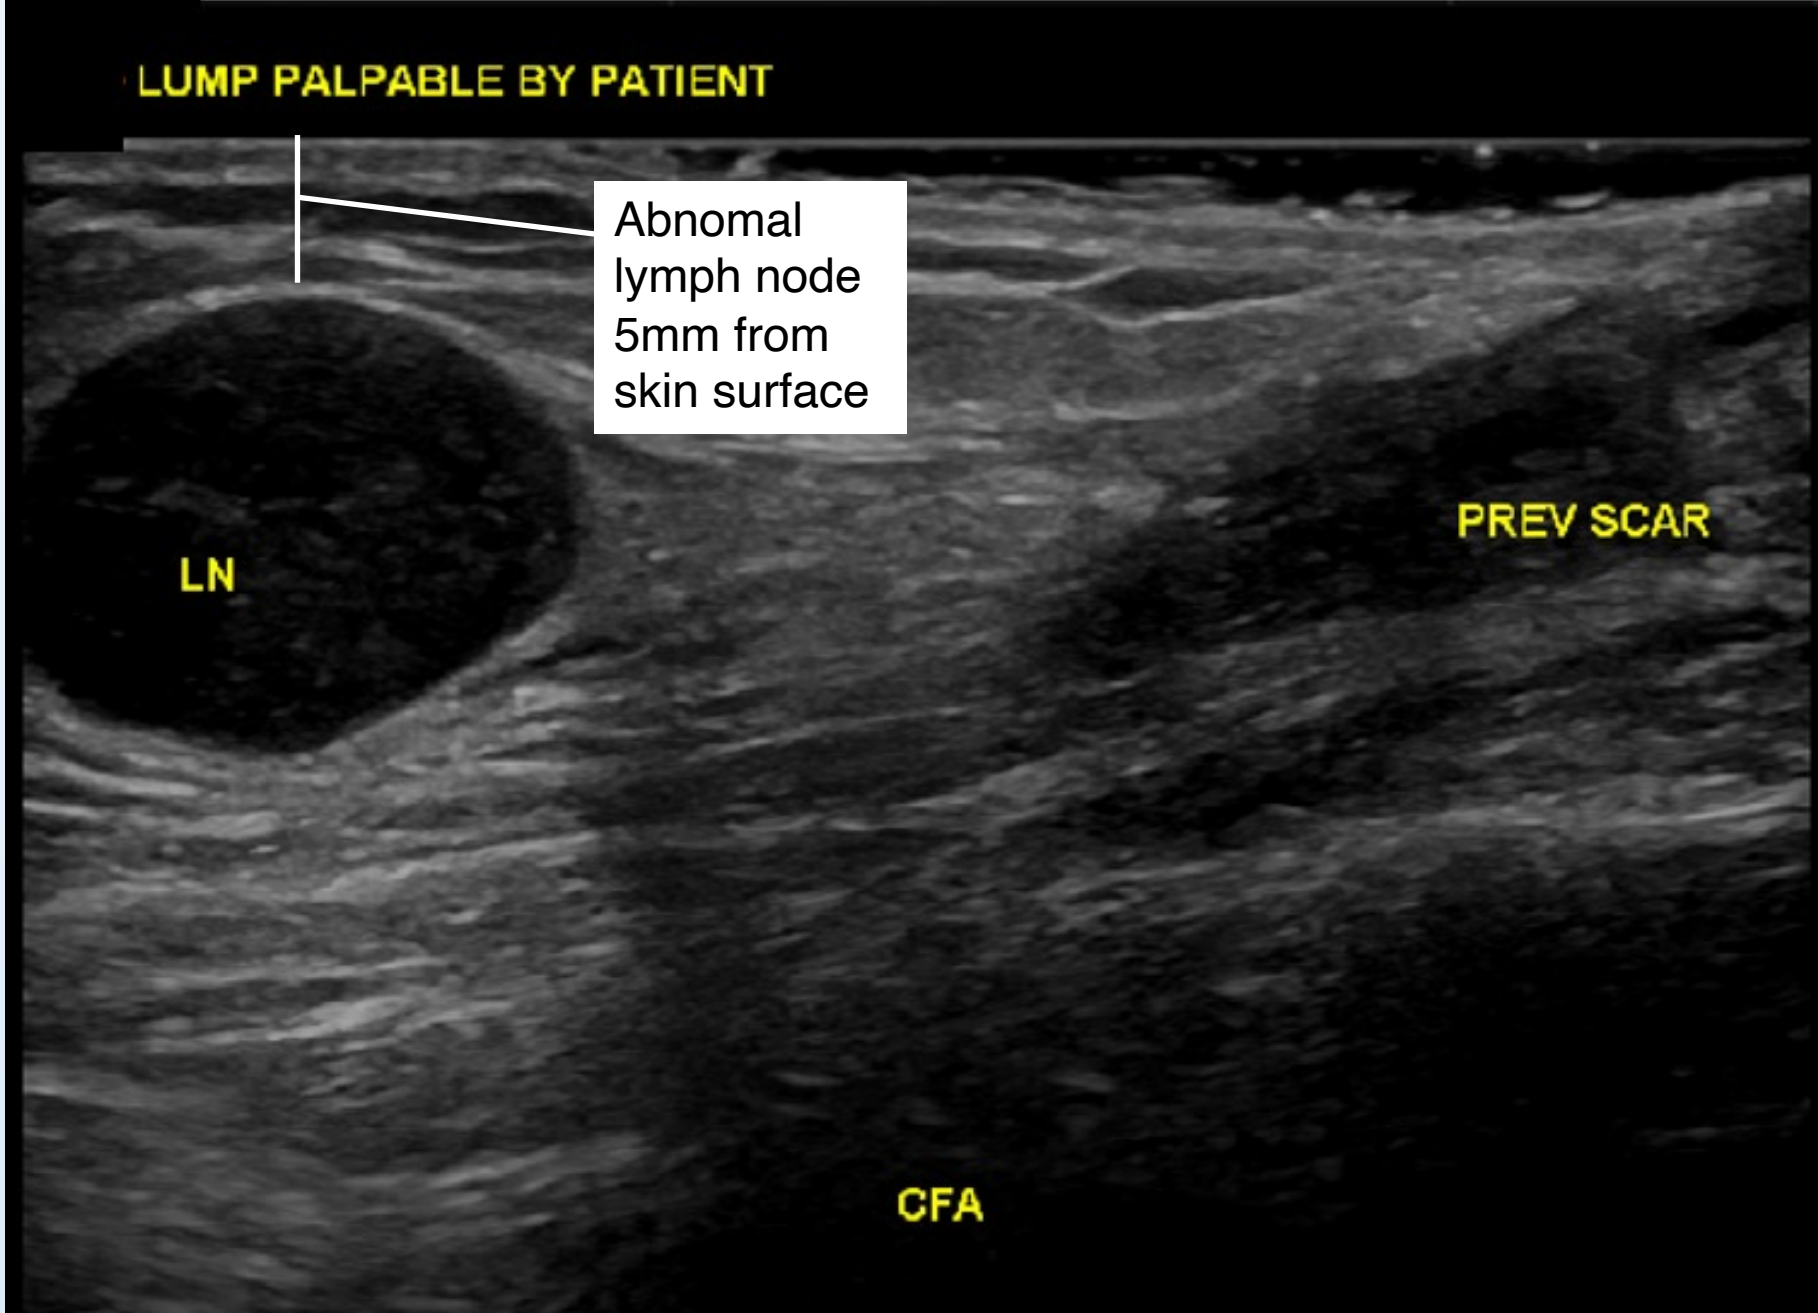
Ultrasound provided key details regarding location for biopsy. Suspicious lymph node lies adjacent to scar, anterior to common femoral artery (CFA) and is only 5mm below the skin surface.
